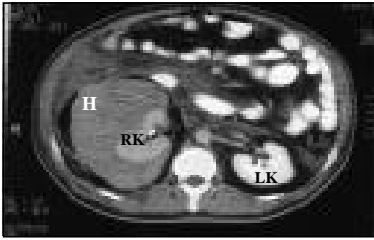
Large subcapsular hematoma in the right kidney on abdominal CT (H - hematoma, RK - right kidney, LK - left kidney).
